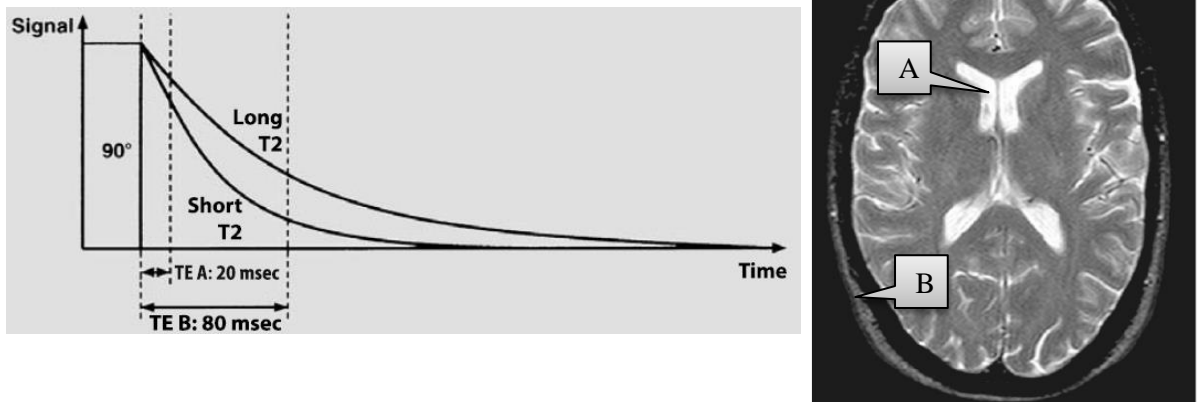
T2 contrast. Left panel: Tissues with short T2 relaxation time (fat) decays faster than those with longer one (CSF) (adapted from (Koechli et al., 2006)). Right panel: T2-weighted spin echo image through the brain. It shows the bright CSF (A) and darker fat (B) (adapted from (Westbrook et al., 2011))
